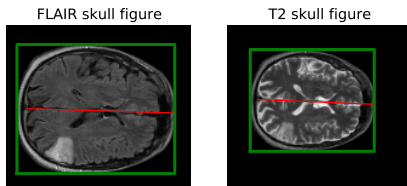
FIGURE – Skulls properties in FLAIR and T2
